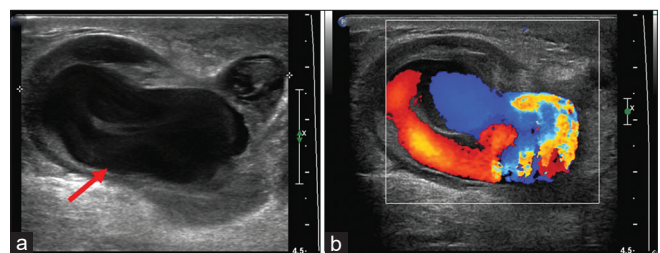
Follow-up transverse (a) and color Doppler (b) US after the biopsy show a complex echoic lesion with an anechoic center (arrow) and whirling blood flow in the lesion
